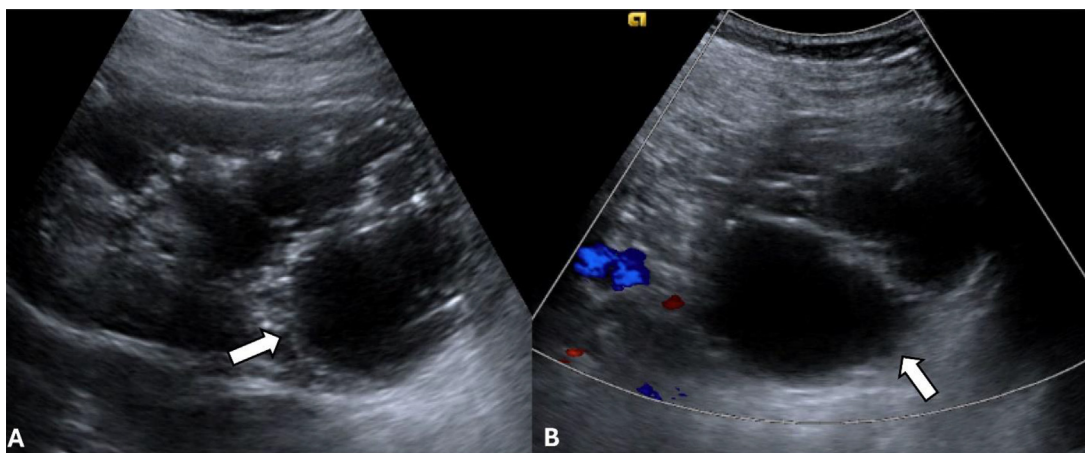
Ultrasound of the right kidney with a hypoechoic cystic structure (white arrows) in the lower pole (A). There are no regions of increased vascularity on doppler (B).
